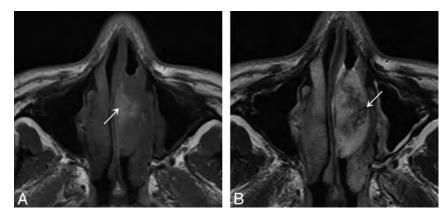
Man, 44 years old. *A*, Axial TI-weighted MR imaging shows a heterogeneously isointense signal mass in the left nasal cavity with patchy high signal area (\nearrow), corresponding to hemorrhage. *B*, Lesion shows heterogeneously hyperintense on axial T2-weighted MR imaging with multiple flow voids (\checkmark).
